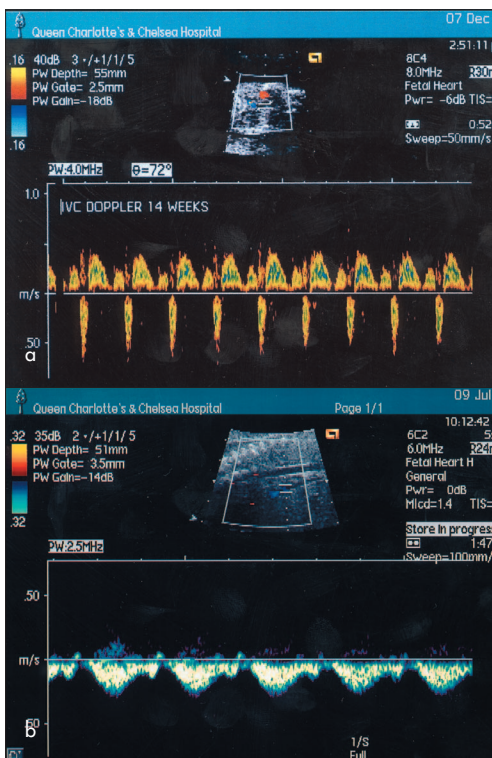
a. Early Doppler (12 weeks) in the fetal descending aorta (AoD) shows absent end-diastolic flow because of high distal impedance as a result of high placental resistance. As successful trophoblastic invasion of the placental spiral arteries occurs the impedance falls and diastolic flow is apparent in the arterial tree (b) as seen in this normal umbilical cord Doppler tracing.
